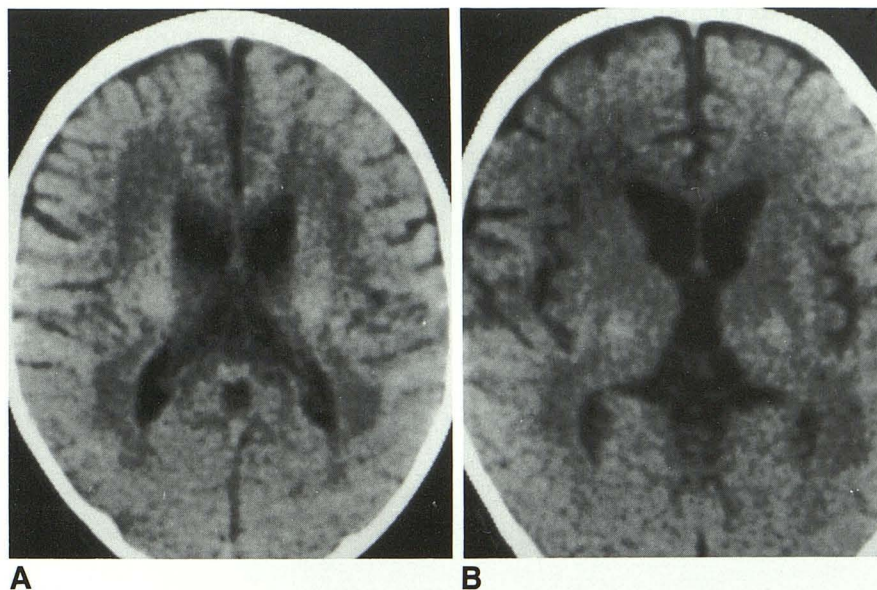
Globoid cell leukodystrophy; axial CT sections through the corona radiata (A) and internal capsules (B). There is high density in the thalami and adjacent parts of the corona radiata, abnormally low density in the deep cerebral white matter, and mild diffuse cerebral atrophy.
